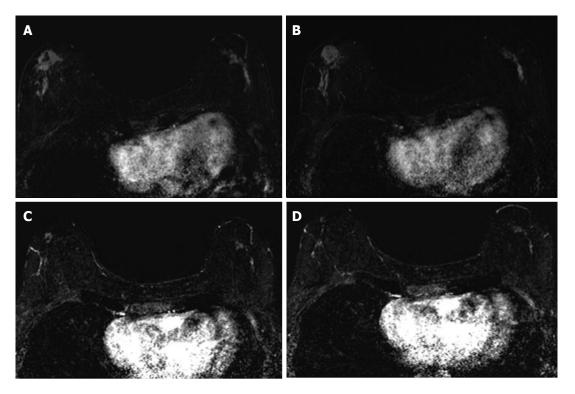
Sixty-four years old woman with bilateral HR+ breast cancer. A and B: Baseline axial T1-weighted post-gadolinium fat-saturated magnetic resonance image demonstrates 3.2 cm irregular mass and contiguous non-mass enhancement (NME), spanning up to 7.2 cm, in the right central outer breast and 3.5 cm of clumped linear NME in the central outer left breast; C and D: Post-neoadjuvant chemotherapy magnetic resonance imaging demonstrates decrease in size of the right breast mass and NME. NME in the left breast demonstrates only mild improvement. Surgical pathology demonstrates 4.3 cm of residual disease on the right and 3.7 cm of disease on the left.
